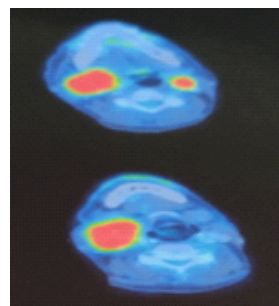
PET scan showing FDG avid cervical mass
